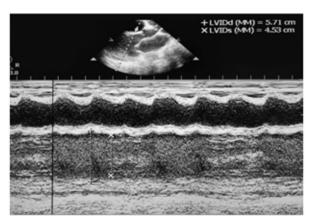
Echocardiography showed a dilated left ventricle.
